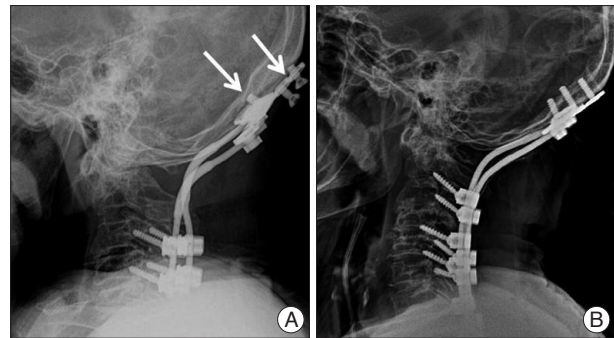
Occipital screw failure in cerebral palsy patient. A : Occipital screw failure occurred at occipital plate during follow up period. B : Post reoperation plain X-ray.
